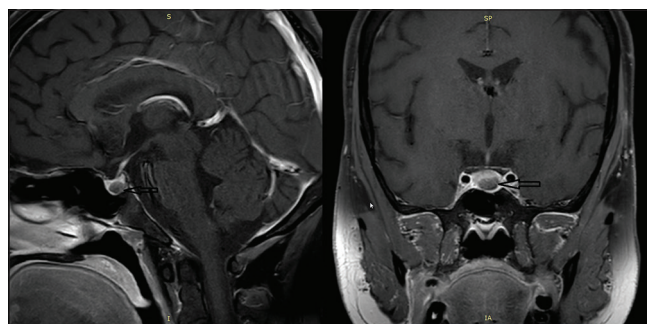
MRI sella (sagittal and coronal views) showing 8 mm pituitary microadenoma (arrow)
